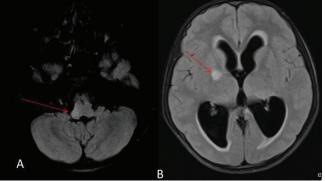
MRI brain showing hamartoma in medulla on right side (A) and right globus pallidus(B) appearing hyperintense on FLAIR.
